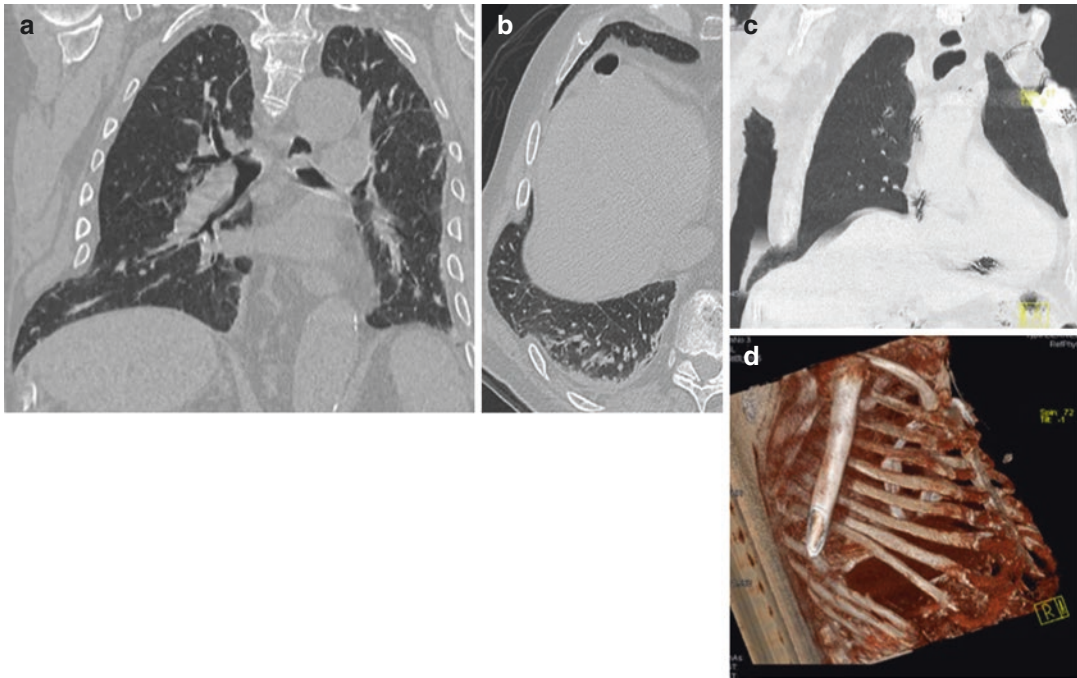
Same patient as in Fig. 8.26: CT confirms the herniation and enables to evaluate the chest wall disruption: coronal (a), axial (b), minimum intensity projection (c), and 3D reconstructions (d)
